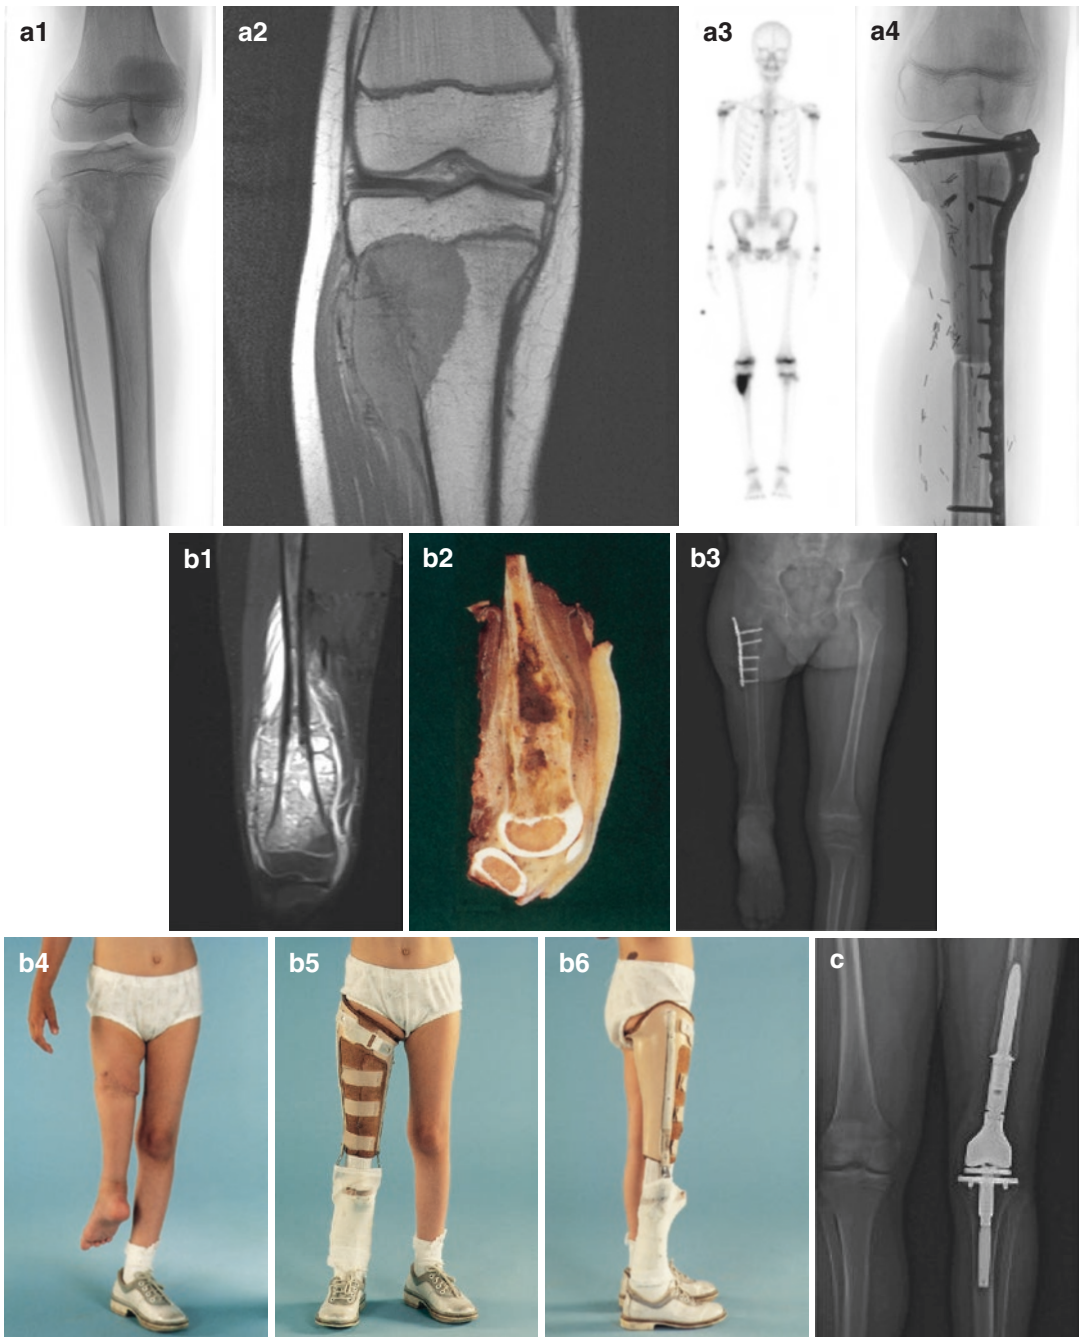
(a1) Osteosarcoma on the lateral side in the proximal part of the tibia. Characteristic is the osteolysis with destruction of the cortex, subperiosteal reaction (onion peel), Codman triangle and a moth-eaten-away part. (a2) MRI image. (a3) Bone-scan. (a4) Resection of the tumor, vascularized fibula allograft to bridge the defect supported with a plate osteosynthesis. (b1) MRI with osteosarcoma in the distal part of the right femur. (b2)
